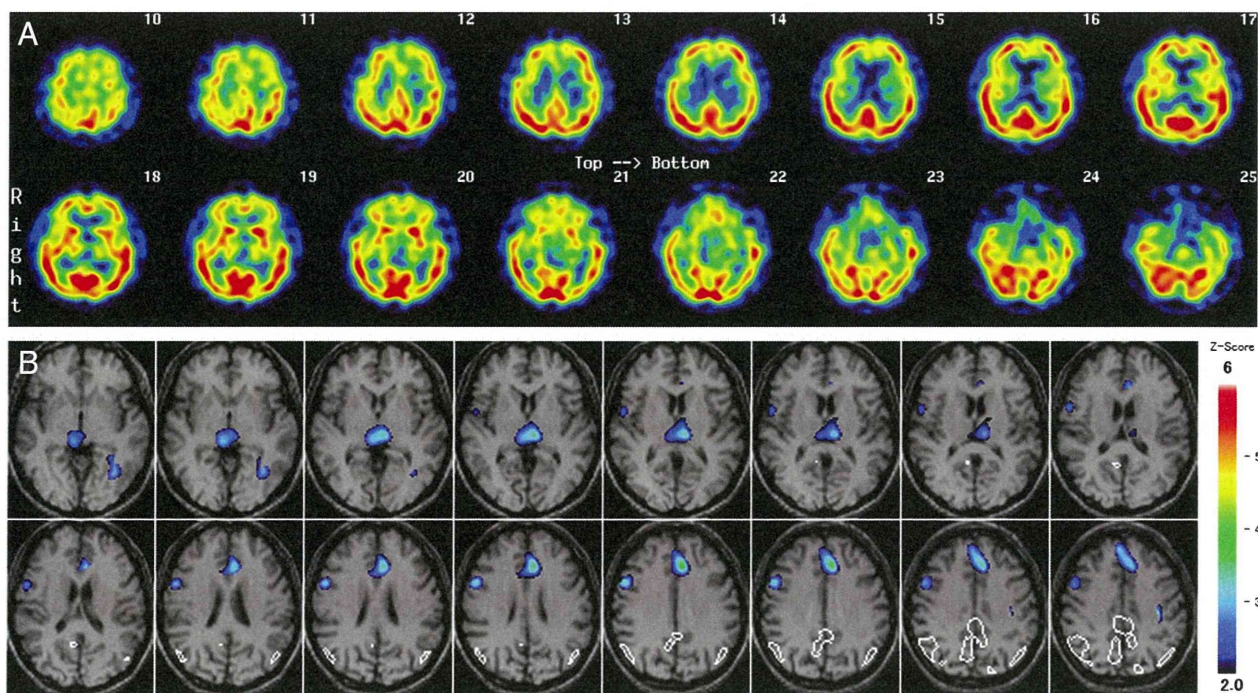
Brain SPECT showed hypoperfusion in the bilateral thalamus with a left predominance as well as the medial frontal lobe cortices (A). Images of eZIS demonstrated regions showing a Z-score of 2 or more in the medial frontal lobe cortices and thalamus (B).
